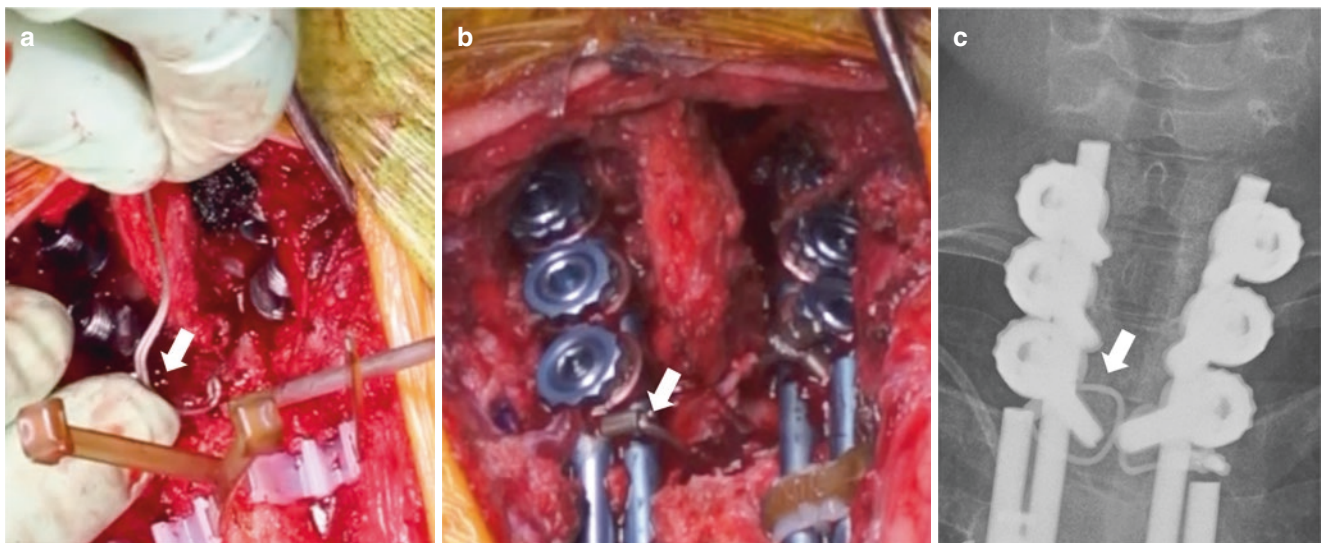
(a) Wires are inserted not through the standard midline ligamentum flavum resection but rather by a small lateral laminectomy leaving the periosteum intact (arrows). (b) Example of apical sublaminar wires capturing the overlapping rods. (c) Radiographic image of wires
